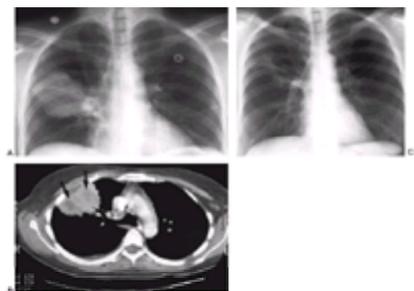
A: Wegener's granulomatosis. PA chest radiograph demonstrates right upper lobe mass in a 36-year-old woman with leukocytoclastic vasculitis, fever, sinusitis, and cough. B: CT in the same patient reveals a mass lesion in the anterior segment of the right upper lobe with areas of focal necrosis (arrows). Transbronchial lung biopsies demonstrated granulomatous vasculitis with extensive necrosis and a polymorphous inflammatory cell infiltrate consistent with Wegener's granulomatosis. C: PA chest radiograph from same patient 5 weeks after initiation of therapy with cyclophosphamide and prednisone, showing nearly complete resolution of right upper lobe mass.
